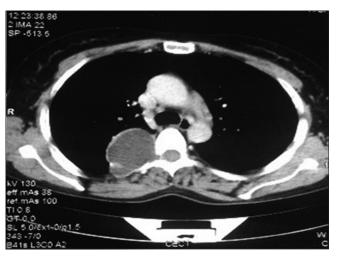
Computed tomography thorax showing erosive widening of the right D4–D5 neural foramen by a cystic lesion
